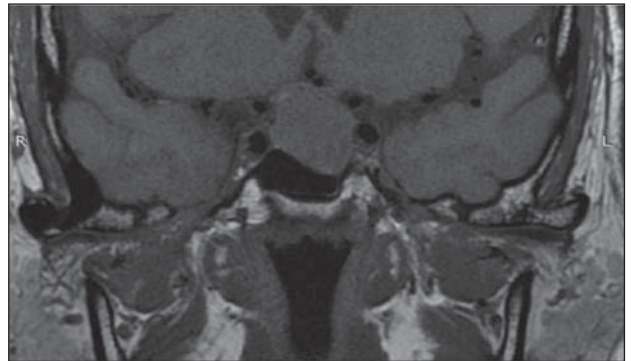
Magnetic resonance imaging: a 15.4/26.7/19.5 mm pituitary mass, with suprasellar and parasellar extension on a 69 year-old male patient
